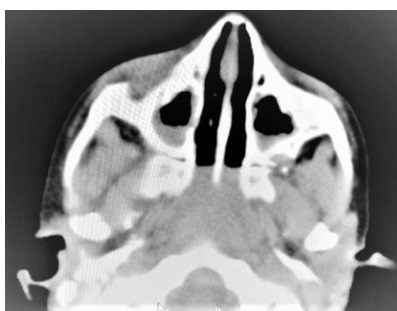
CT scan showing bilateral maxillary sinusitis
